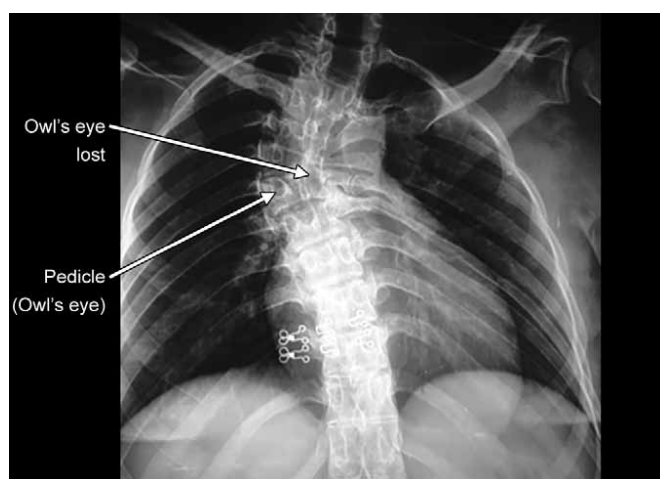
X-ray of scoliotic spine showing loss of owl's eye appearance.
